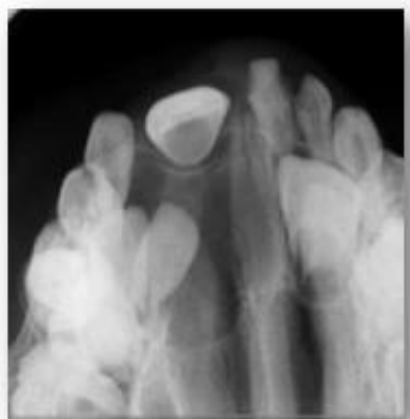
Anterior maxillary occlusal radiograph
